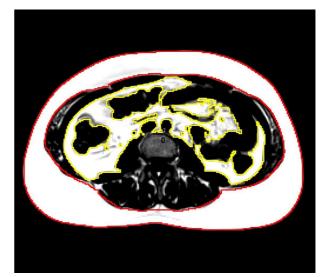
Example of axial fat-only Dixon MR image and VAT and SAT segmentation by FATCALC. In the axial fat-only Dixon MRI image obtained from the level of the L3 vertebral body, subcutaneous and visceral fat tissues can be easily distinguished. FATCALC software automatically selected areas of adipose tissue (red contoured area, subcutaneous adipose tissue; yellow contoured areas visceral adipose tissue).
